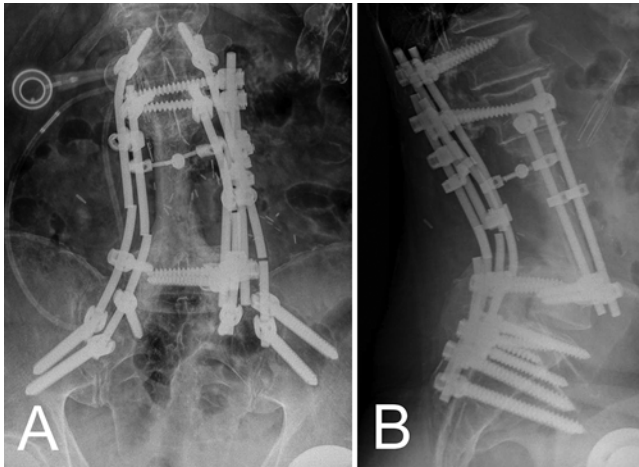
Anteroposterior (A) and lateral (B) radiographs obtained in a patient with union of the FVFG, showing hypertrophy at docking sites; however, implant failure occurred 3 years after primary resection of the L2–5 vertebrae for chordoma, with multiple broken rods without screw loosening.
